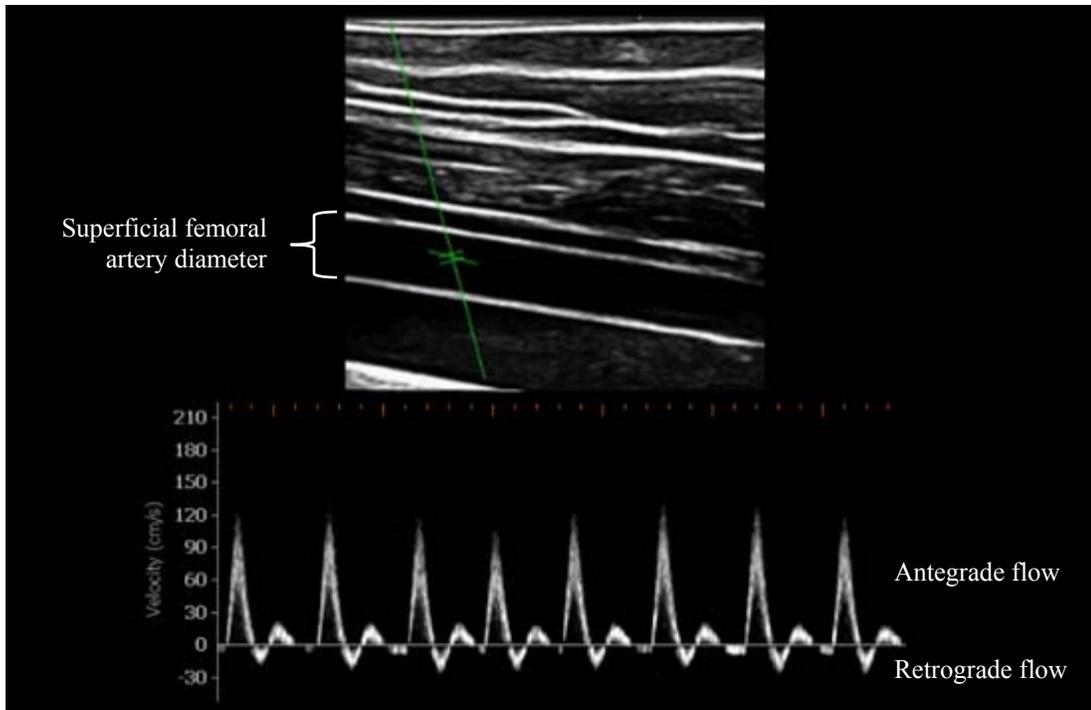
Shear patterns in the superficial femoral artery using ultrasound Doppler imaging. B-mode produces real-time images of the conduit artery, represented in the top half of the figure. The cursor (*green cross in the center of the vessel*) provides a measure of the blood flow velocity via spectral Doppler analysis, represented in the bottom half of the figure.
